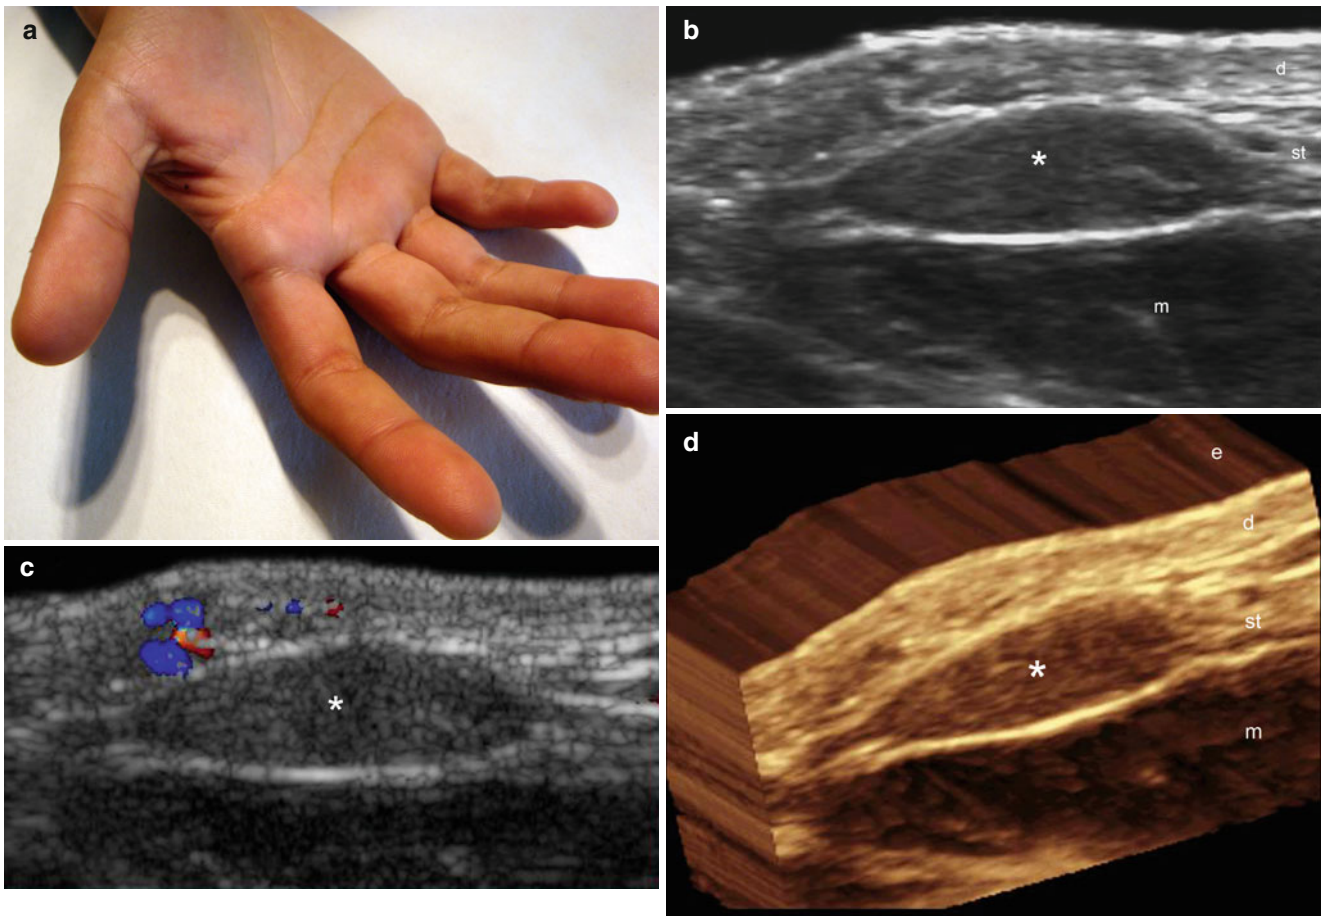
(a–d) Localized neurofibroma. (a) The patient presented with a palpable lump in the right thenar eminence. (b) Grey scale ultrasound image (transverse view) shows well-defined, oval-shaped, hypoechoic nodule (*) in the subcutaneous tissue. An afferent hypoechoic tract is detected in the left side of the nodule. (c) Color
